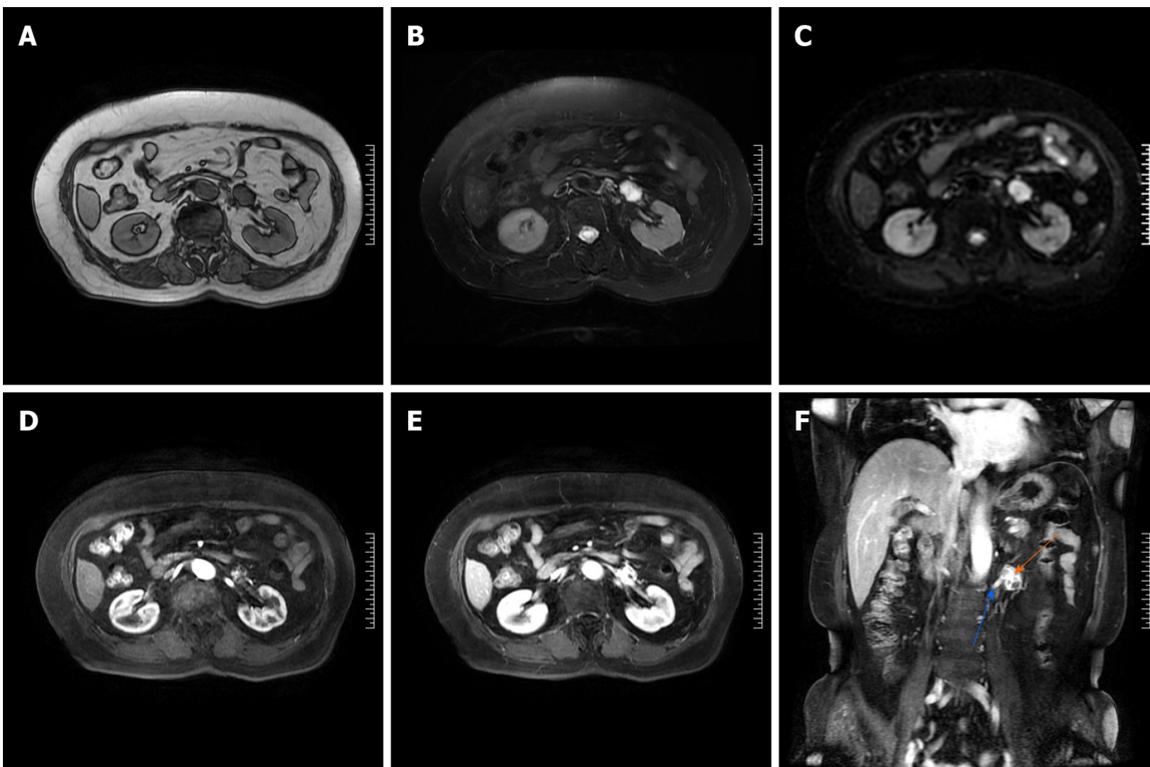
Anastomosing hemangioma of left renal vein on magnetic resonance imaging. A: T1-weighted image; B: T2-weighted image; C: Diffusion-weighted image; D: Arterial phase post-contrast T1-weighted image; E: Portal venous phase post-contrast T1-weighted image; F: Coronal portal venous phase post-contrast T1-weighted image. Orange arrow marks the anastomosing hemangioma, and blue arrow marks the left renal vein.
